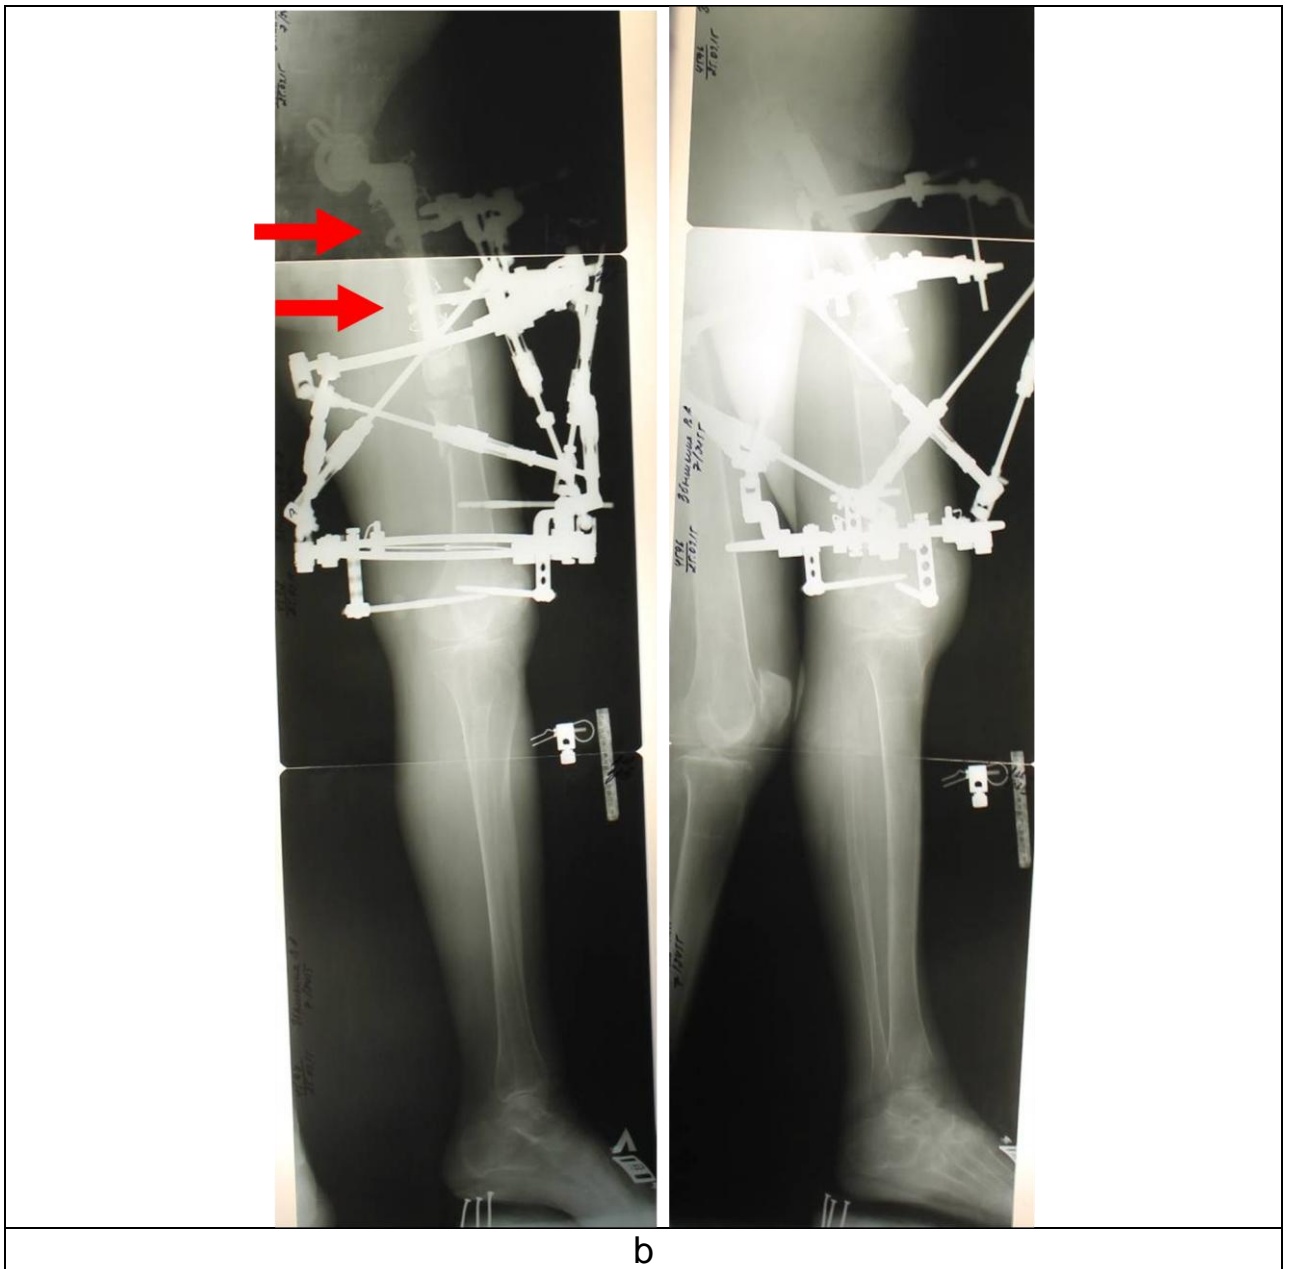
X-rays of patient L., 66 y.o., with periprosthetic non-union of the femur: a – before the surgery; b – after plate removal and external fixation (SUV-clamps are pointed by arrows); c – after consolidation
